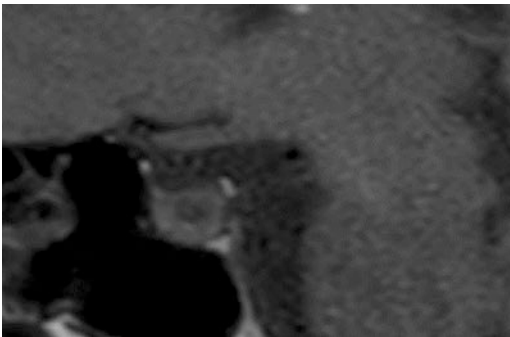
T1-weighted MRI imaging of a pituitary microadenoma, sagittal image
